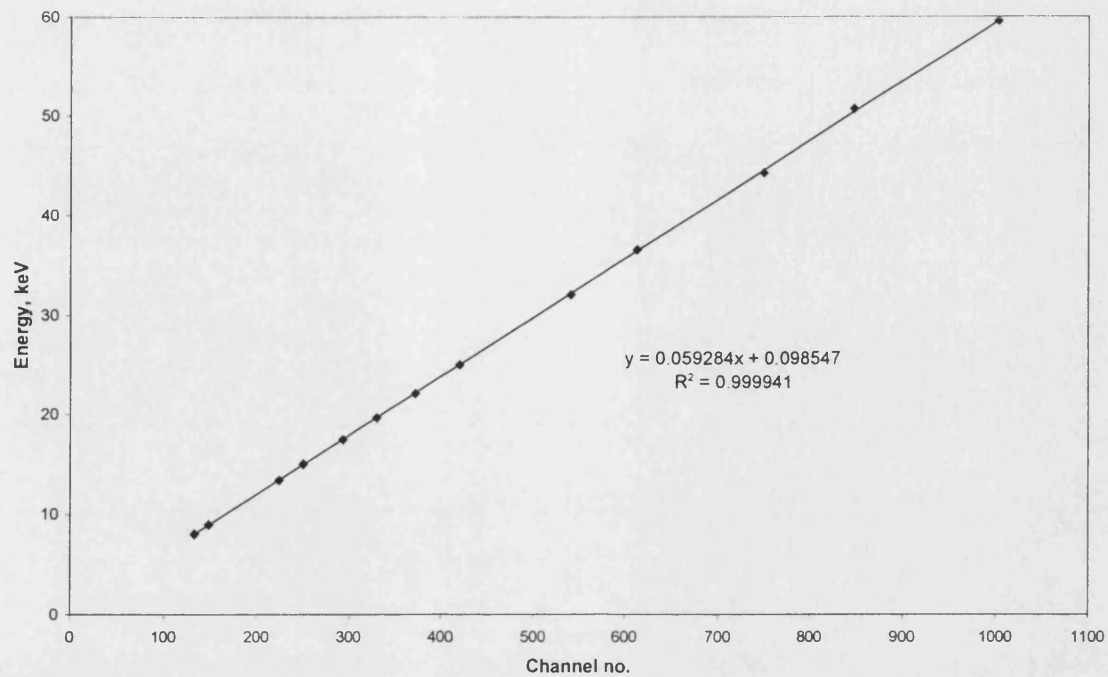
Linearity of detection system measured with variable energy americium-241 x-ray source
